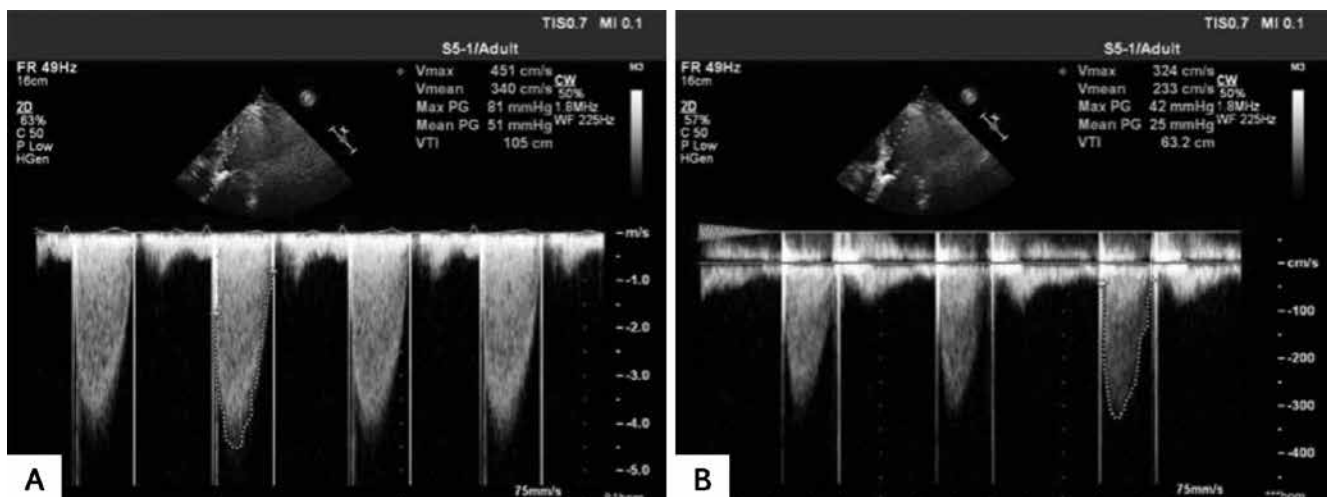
(A) Transthoracic echocardiography (TTE) continuous wave Doppler analysis showed increased maximal and mean aortic transvalvular gradients before thrombolytic therapy (TT) on admission. (B) TTE continuous wave Doppler analysis showed normal maximal and mean aortic transvalvular gradients after TT.
